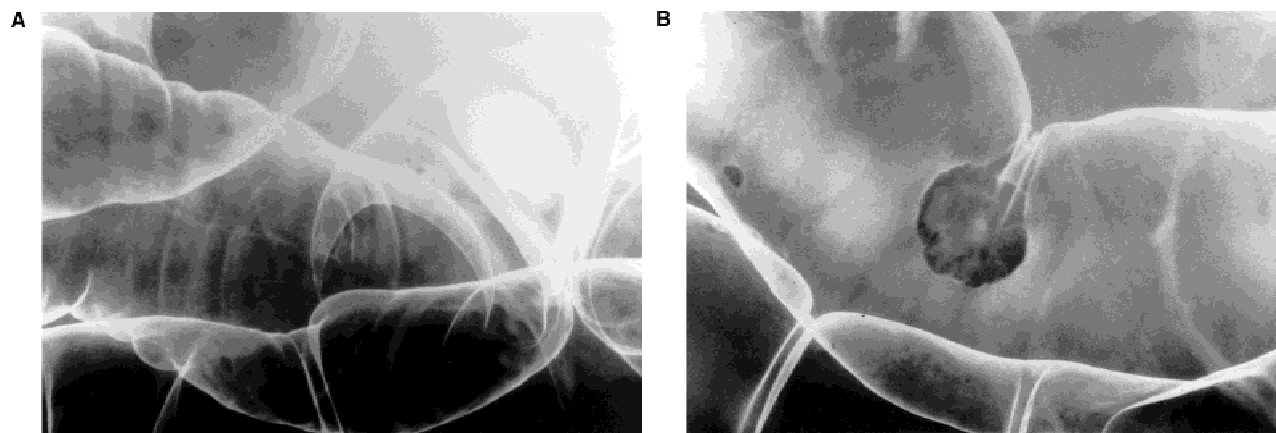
Case presentation: 73-year-old man. A: X-ray obtained on 17 August, 1991. A superficial, elevated lesion 7 mm in diameter with a central shallow depression is demonstrated. B: Sixteen months later, the lesion increased to 19 mm in diameter. The calculated DT of this lesion is 3.7 months.
